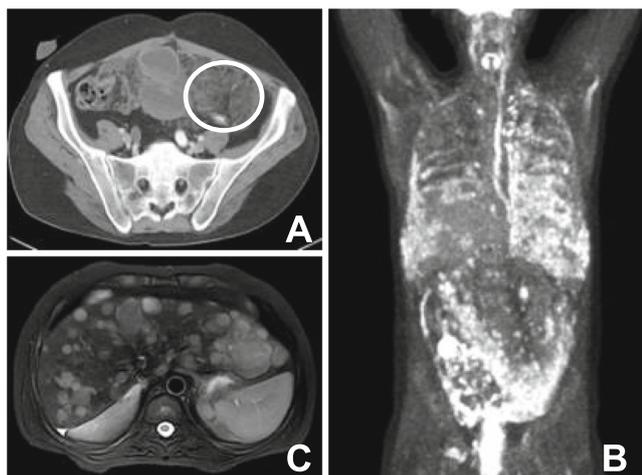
Clockwise from top left: A. CT imaging highlighting omental radiodensity, B. PET/CT showing extensive hypermetabolic activity, C. CT of the liver showing multiple focal lesions
